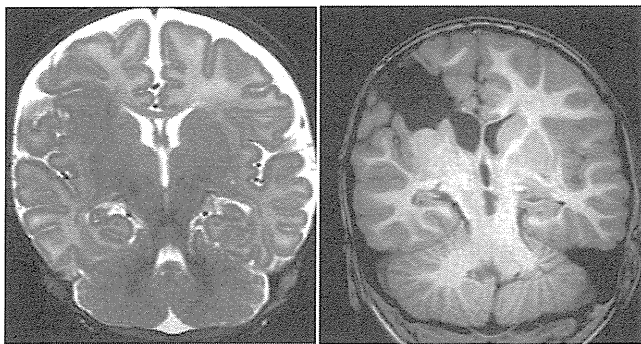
Focal resection indicated for a bottom of sulcus FCD type in the frontal lobe. All MRI-visible lesions that invaded to the periventricular white matter and parts of the insular cortex and striatum were completely resected. (Left) pre-op, and (right) post-op.
